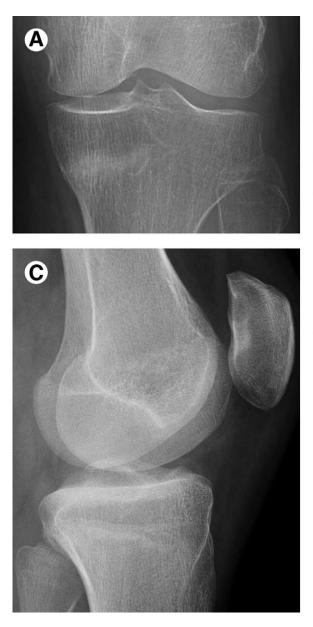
(A, B) Anterior and lateral views of the knee demonstrate a lateral tibial plateau fracture. The depressed fragment is easier to see on the lateral view (arrow) since the cortical edge is not tangential to the X-ray beam on the AP view. There is loss of the cortical margin and a "smudgy" linear density as clues on the anterior view.
